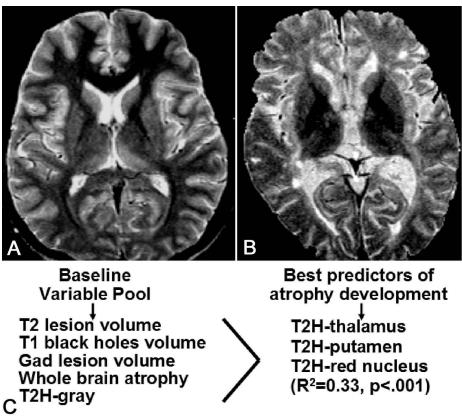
MRI T2 hypointensity (T2H) in the gray matter and brain atrophy in MS. Hypointensity on T2-weighted images has been described in the gray matter of patients with MS and is related to physical disability, clinical course, MRI lesion load, and brain atrophy (8,91,92). The finding most likely represents pathologic iron deposition. Conventional spin-echo T2-weighted images are shown of a normal volunteer (a) and an age-matched patient with secondary progressive MS early in the fourth decade of life (b). In the latter, note the marked hypointensity of the deep gray matter nuclei, including the thalamus and putamen. A natural history longitudinal study (93) of 68 relapsing-remitting patients revealed that T2 hypointensity (T2H) in the caudate, putamen, globus pallidus, red nucleus, and thalamus correlated with baseline brain parenchymal fraction (BPF) (r=.19-.39, p=.001-.029). Baseline T2H in the thalamus, putamen, and globus pallidus predicted 2-year BPF change (r=.26-.33, p=.006-.032) and T2H was chosen in regression modeling as the best predictor of BPF change after accounting for all MRI lesion variables (c). Thus, gray matter T2H predicts progression of brain atrophy suggesting a relationship between iron deposition and tissue destruction in MS.
